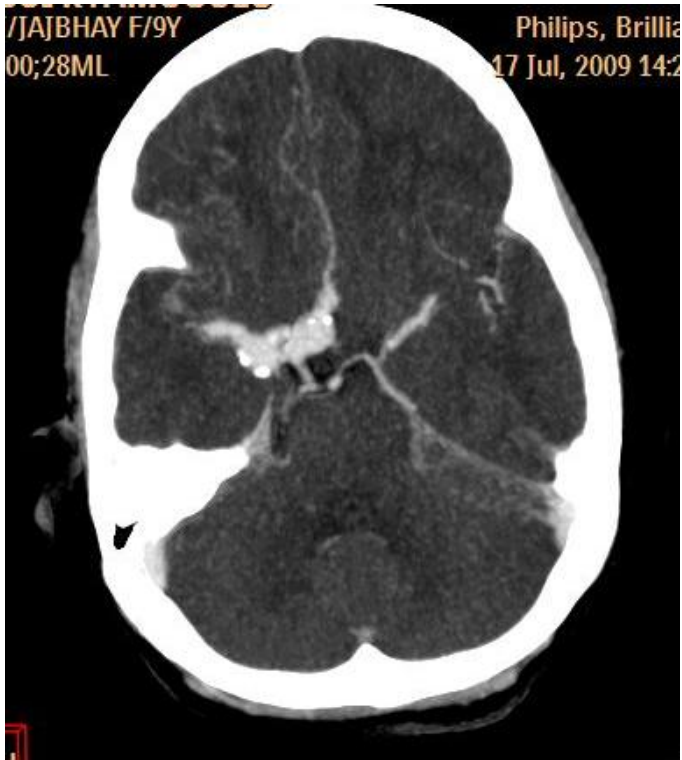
Follow up contrast CT Brain, showing the aneurysm, with areas of calcification
